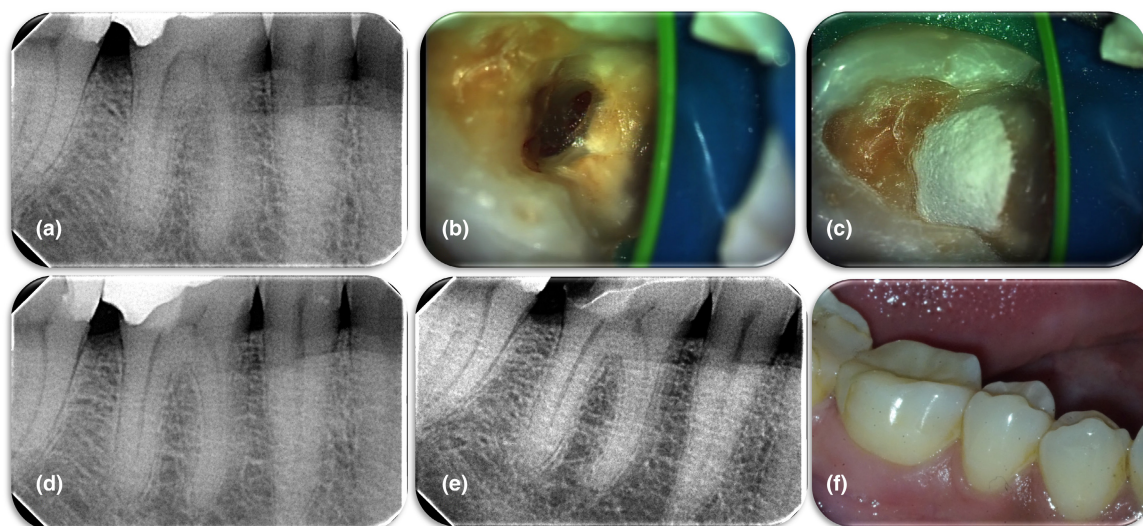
(a) Initial radiograph of a mature first mandibular molar of a 35-year-old patient with symptoms of lingering pain to cold stimulus, (b) clinical figure of the tooth after caries removal and communication with the pulp chamber, (c) placement of MTA Angelus over the coronal pulp tissue, (d) postoperative radiograph of the case. (e) 32-month recall radiograph. An onlay has been placed as permanent coronal restoration, (f) clinical figure of the tooth at 32-month recall examination, no crown discoloration is apparent.
